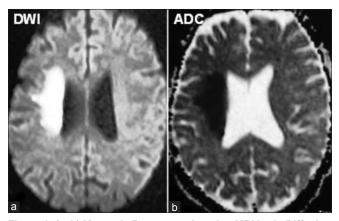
(a, b) Magnetic Resonance Imaging MRI brain Diffusion Weighted Imaging/Apparent Diffusion Coefficient DWI/ADC axial images showing acute infarct in right peri-insular and adjacent white matter
